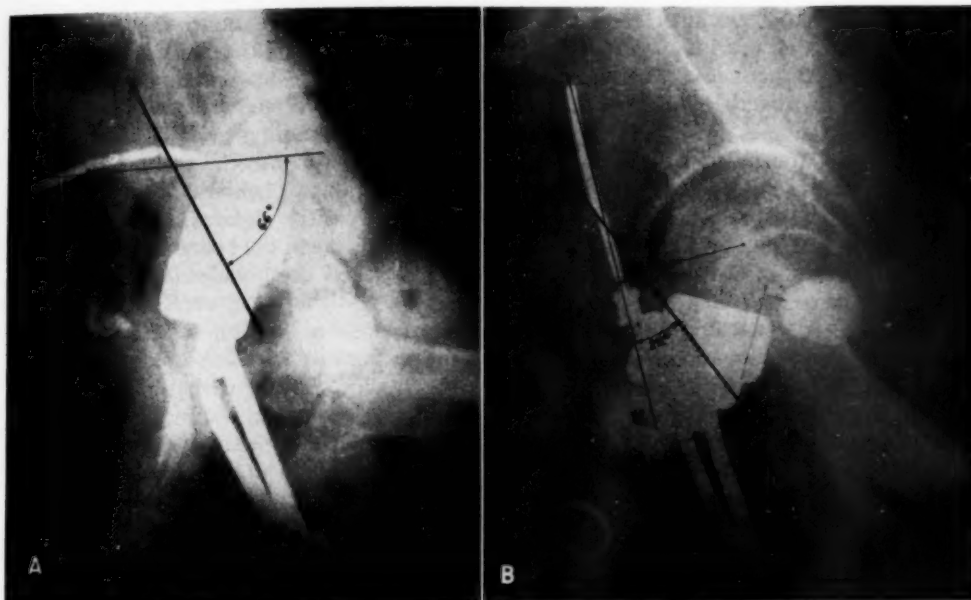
A. Tandem, 15-10-10 mg., and large ovoids, 25, 25 mg. with 3 cm. separation. Despite third-degree retroversion, the maximum rectal dose is 2,980 gamma roentgens (seventy-two hours), at 10 cm. from the anal margin, with a strip of 6 cm. above 2,000 gamma roentgens. Barium or gas shadow is in this case of no help in locating the "hot spots" on the anterior rectal wall.
